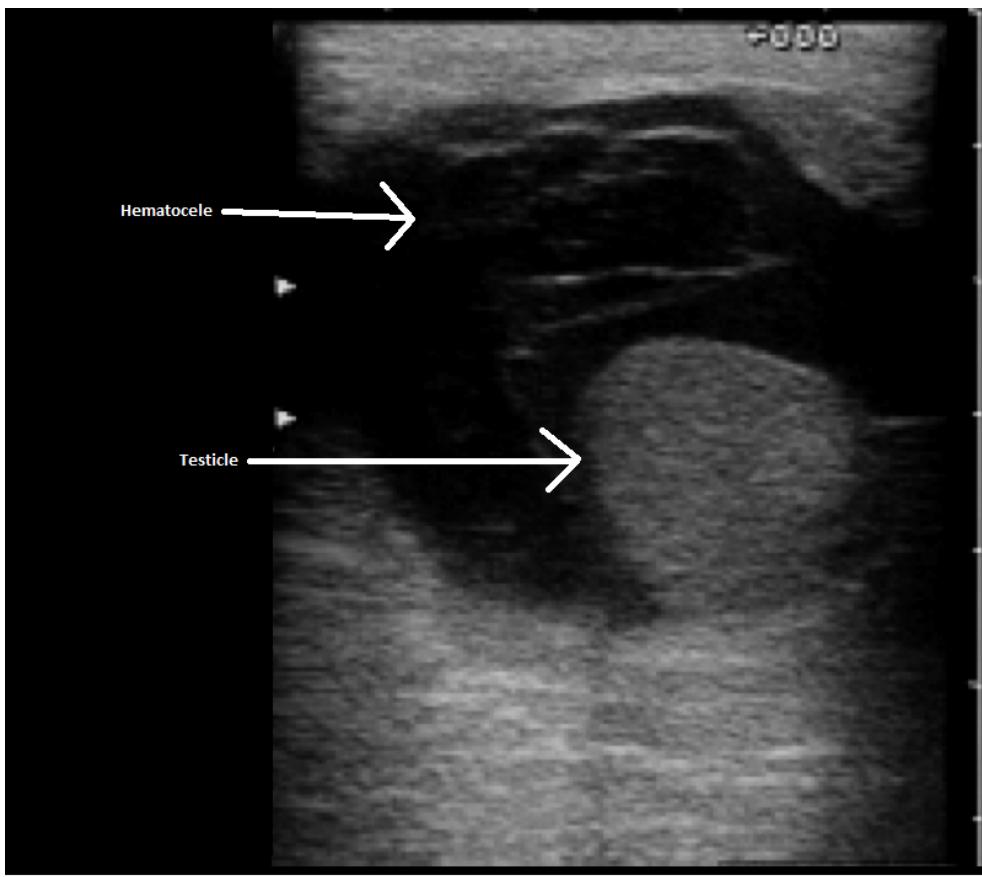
Hematocele. Pictured here is a scrotal ultrasound demonstrating a testicle with a hematocele, appearing as a complex fluid surrounding the testicle.
